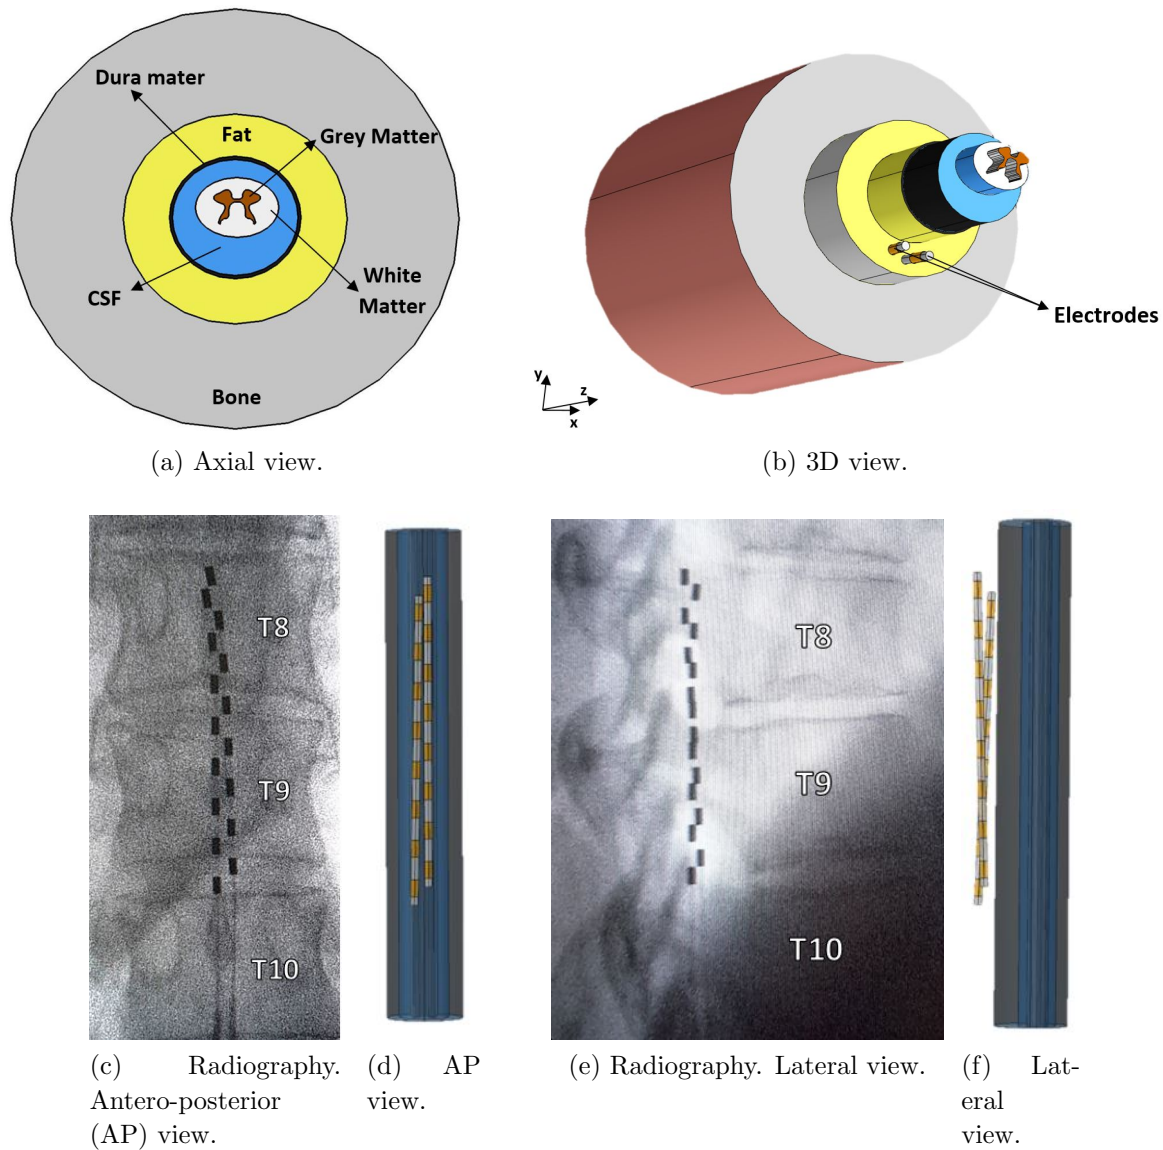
The generalized spinal cord model and electrode X-ray. Fat and bone tissues are hidden to show the location of the electrodes in the computational model. The model's spinal cord geometry is that of T9 (a) and b)). Percutaneous electrode dimensions: length: 53 mm; diameter: 1.3 mm; pole length: 3 mm; intercontact length (insulator): 4 mm; number of poles: 8. X-ray of the electrode taken from the patient (c) and e)), and the location of the electrodes in the generalized spinal cord model (d) and f)).
